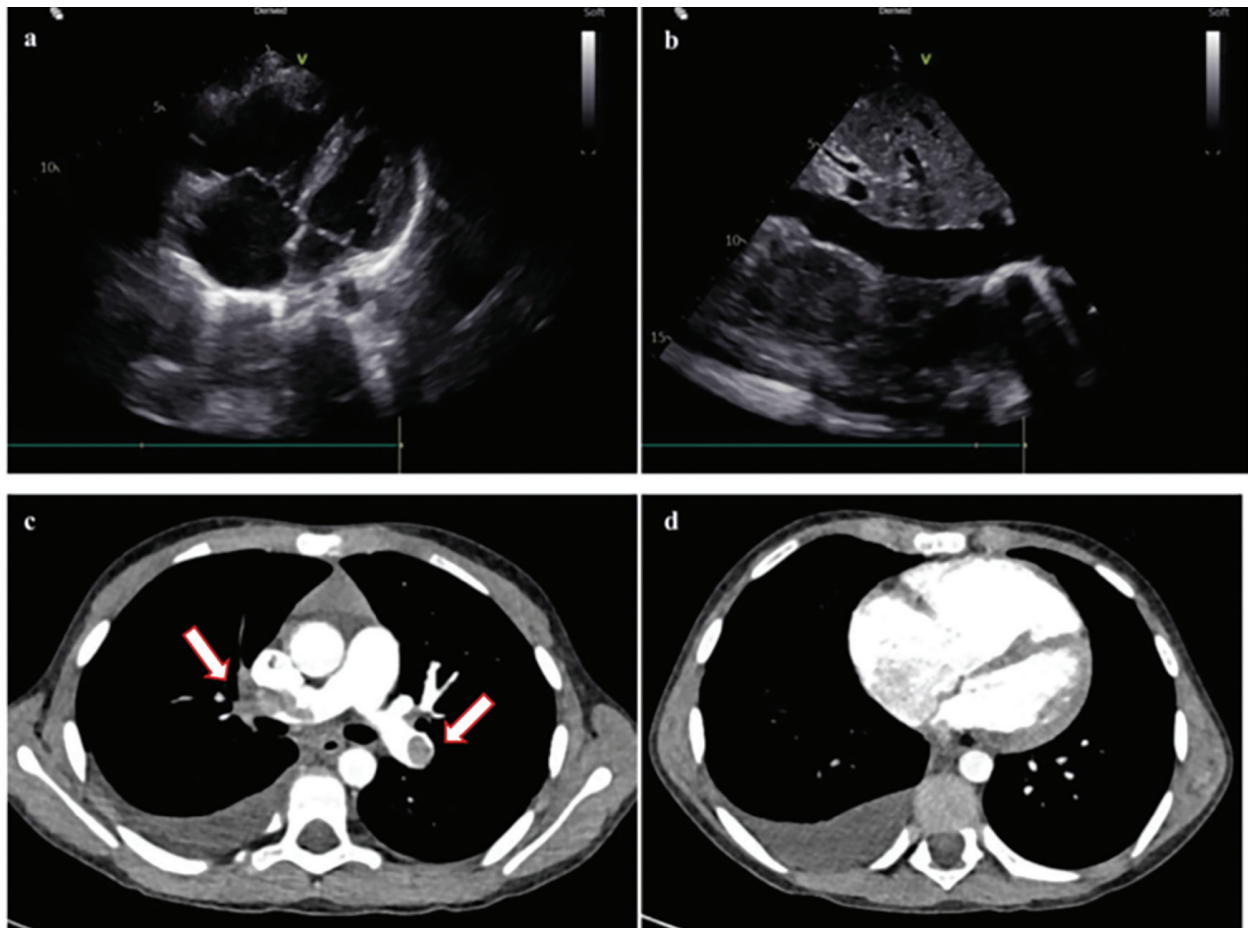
(a, b) Transthoracic echocardiography showing marked right ventricular dilatation and dilated inferior vena cava, consistent with right heart strain. (c, d) CT pulmonary angiography images demonstrating bilateral massive pulmonary emboli with thrombus extending into segmental branches (white arrows), enlargement of the right heart chambers, and right-sided pleural effusion
